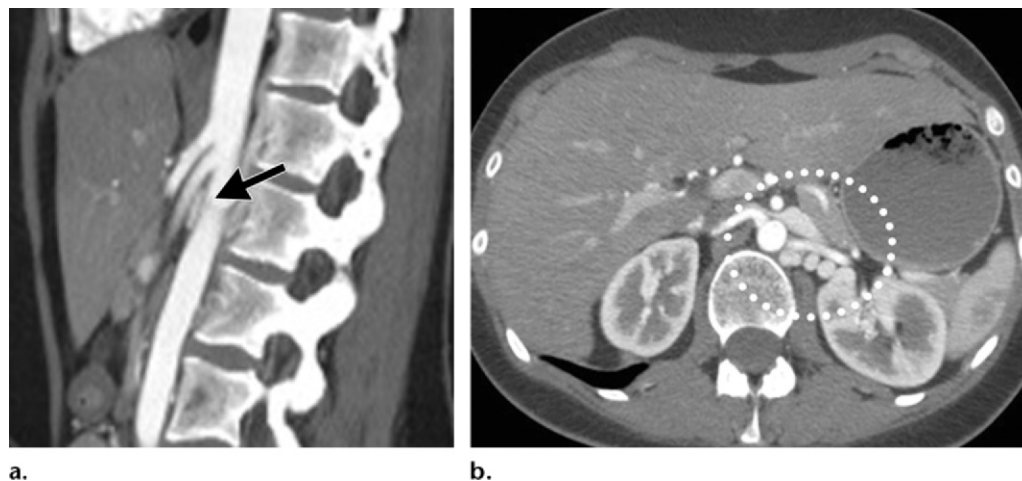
Nutcracker syndrome in a 19-year-old woman with hematuria and left-sided flank pain. Sagittal (a) and axial (b) CT angiograms demonstrate compression of the left renal vein (arrow in a) between the aorta and superior mesenteric artery, with proximal venous dilatation and multiple perirenal collateral vessels (dotted circle in b).
